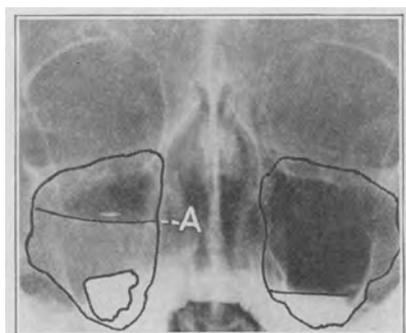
A woman aged 36, with pain over the right temple and the right side of the face and with a discharge of pus from the right naris, had a history of cold of twelve days' duration. On irrigation, thick pus with considerable foul odor was returned. Iodized oil was injected before the cannula was removed, and a roentgenogram showed that the oil gravitated immediately to the bottom of the sinus. Note the oil lying on the thickened membrane, and the water level (*A*) in the right antrum. The left antrum shows normal filling and no infection. The second injection of oil was made four days later, and one week later the antrum was free from pus.
